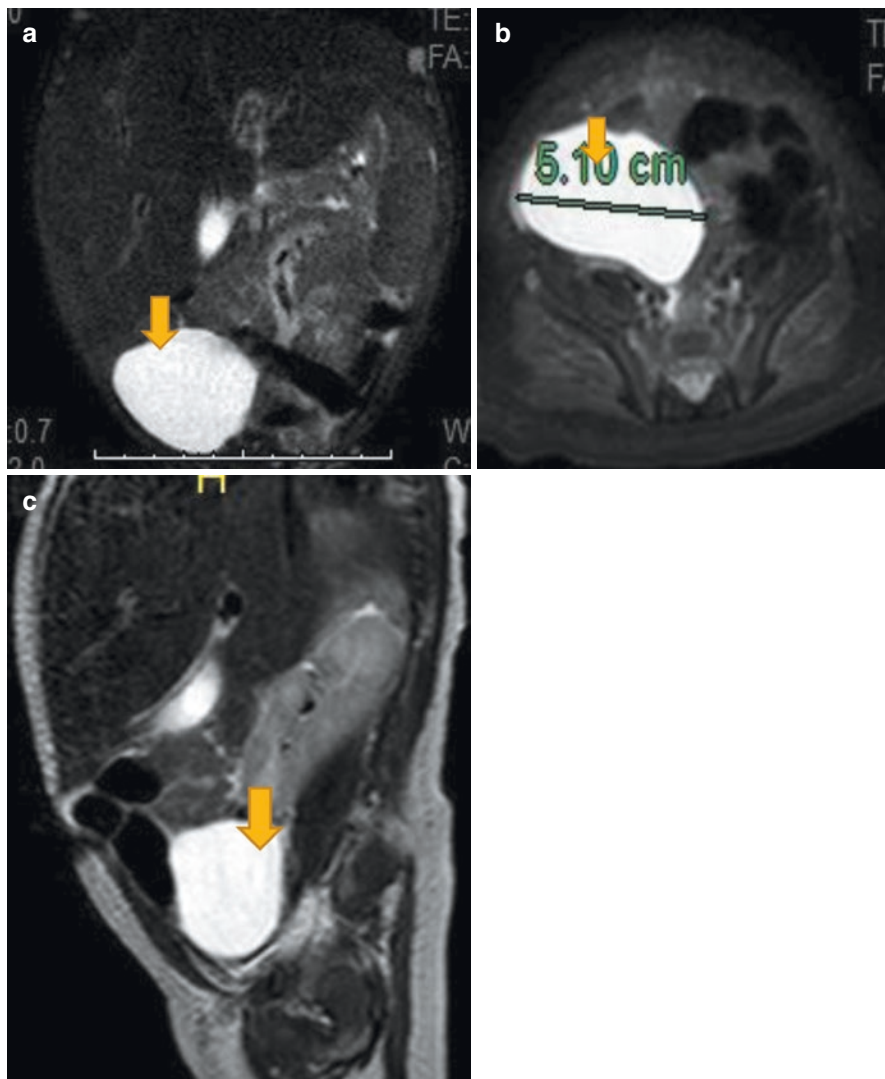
(a–c) Abdominal CT-scan showing a right ovarian cyst in a newborn. This was diagnosed intra-uterine and followed up. Subsequently, the cyst disappeared completely
